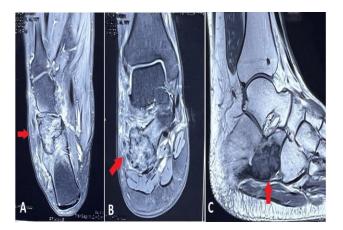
(A-C): Axial, coronal and sagittal sections of the MRI (lesion marked by an arrow).
